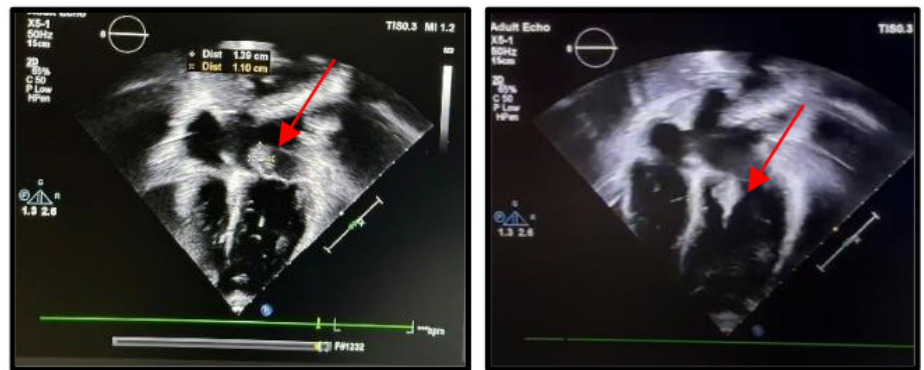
Echocardiography showed vegetation in the mitral valve (red arrow)
